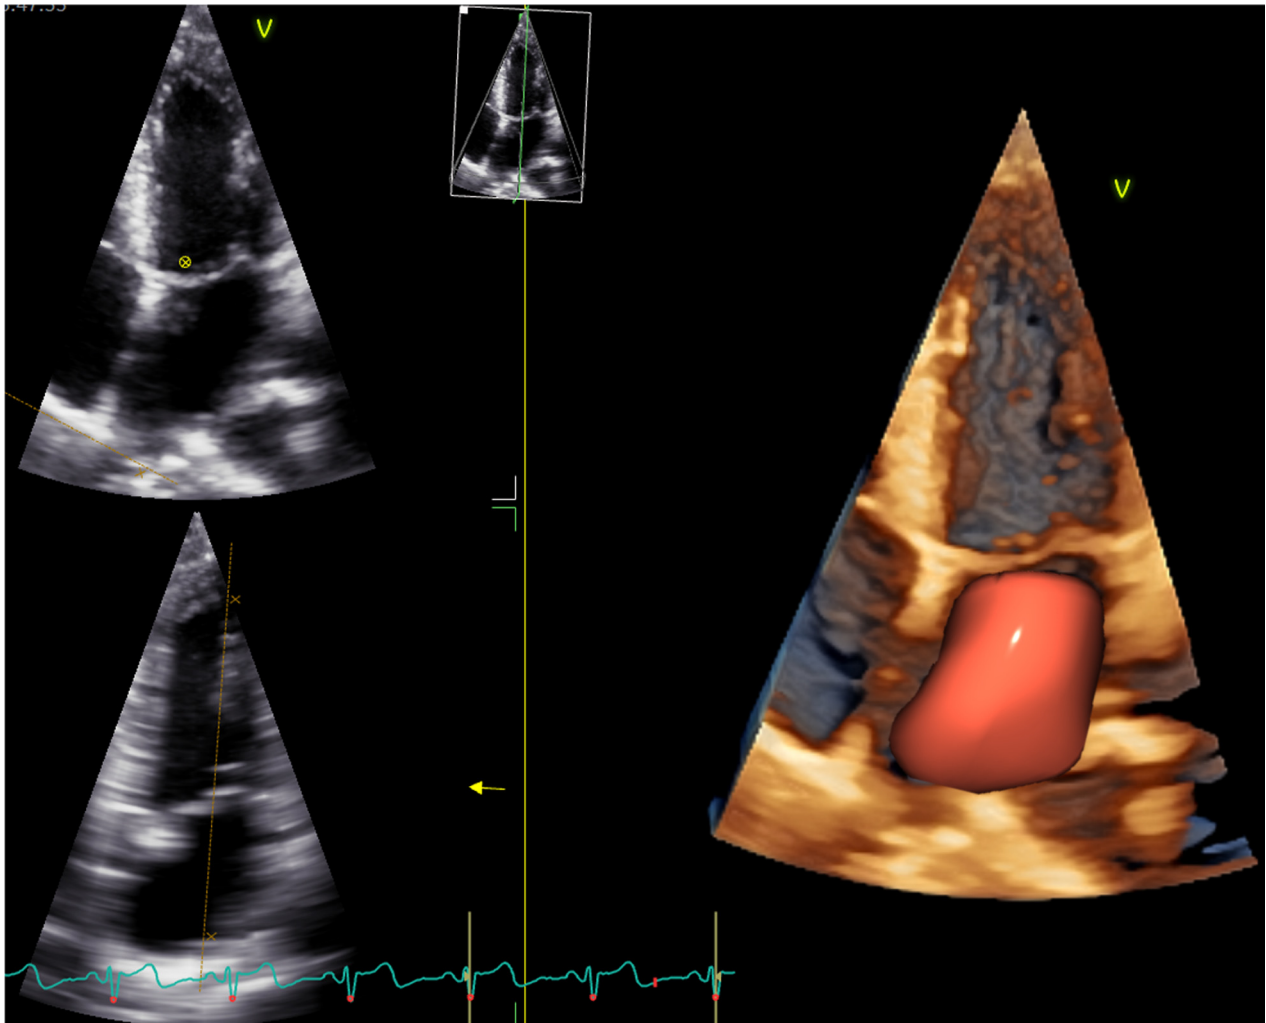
Automated measurements of the LA volumes using 3DE with commercially available software packages that use data sets acquired with the transthoracic approach.
